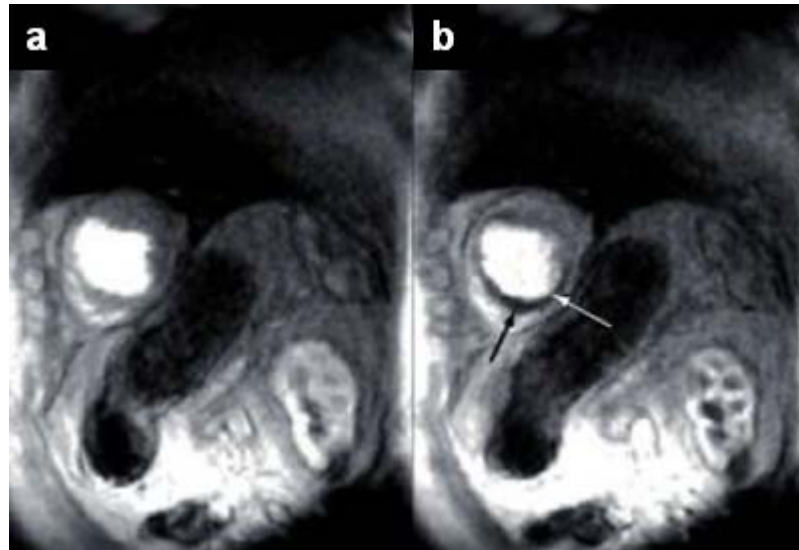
Cardiac MRI. (a) recorded under rest, (b) recorded under stress (arrow head pointing to sub endo-cardial perfusion defect.) [11].
